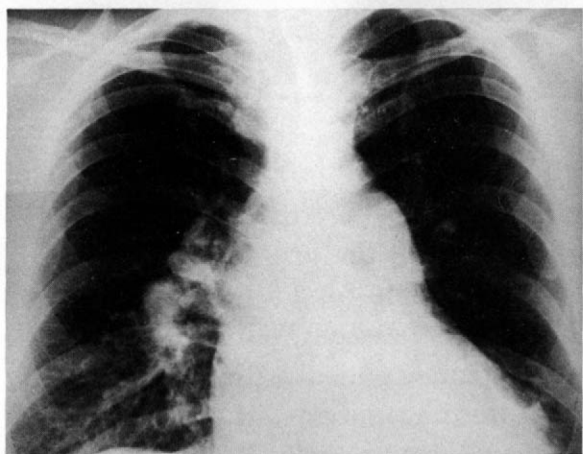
Chest X-ray in 1975 reveals a regional ectatic enlargement of the main pulmonary artery and a higher degree of peripheral tapering.
